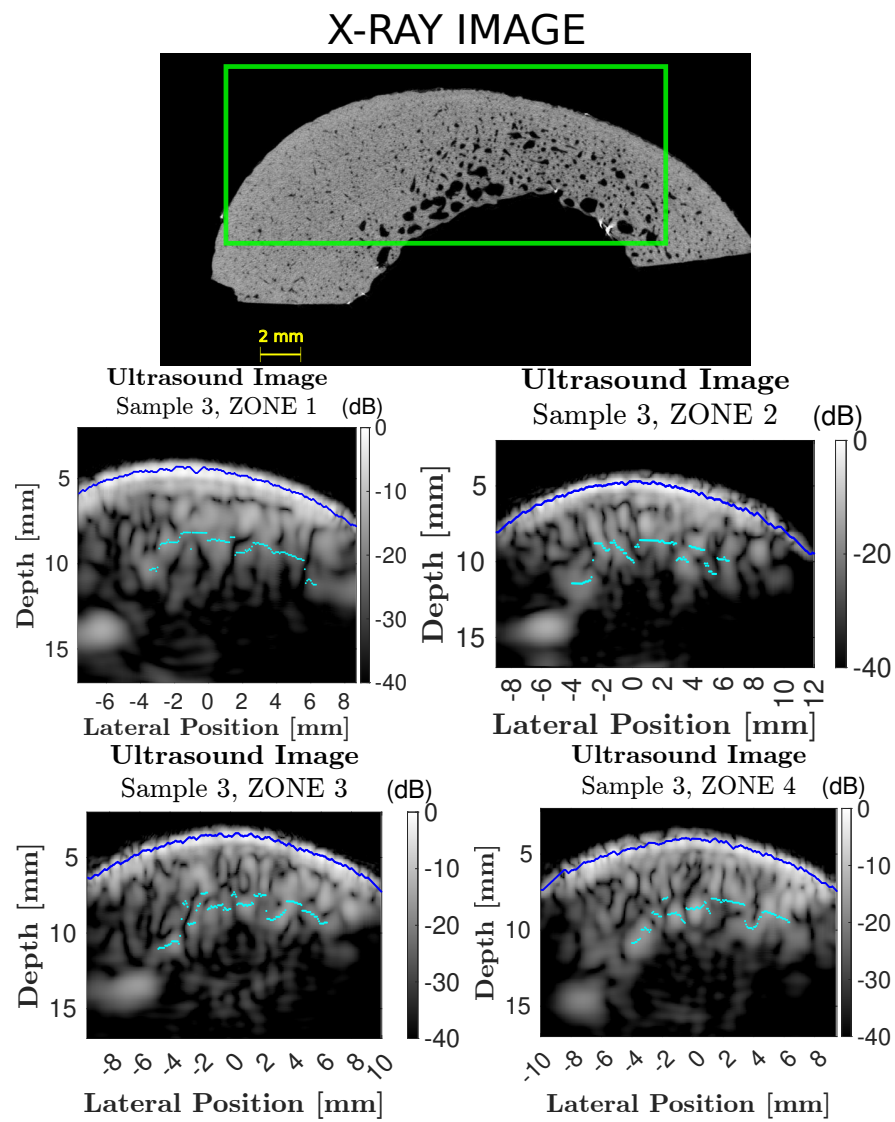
Ultrasound images of each measurement zone of Sample 3.
